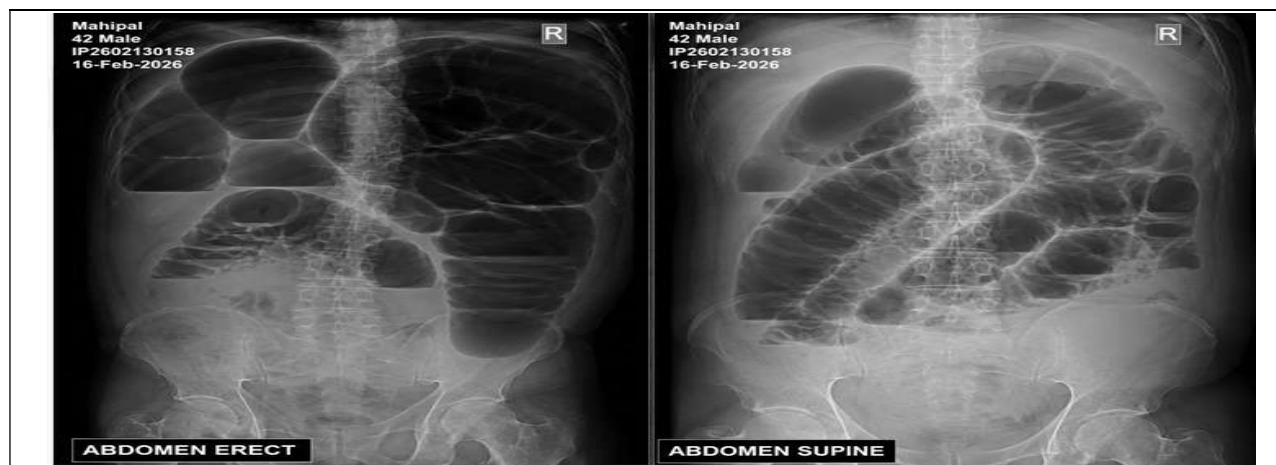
Plain abdominal radiograph demonstrating multiple dilated bowel loops with air-fluid levels.
